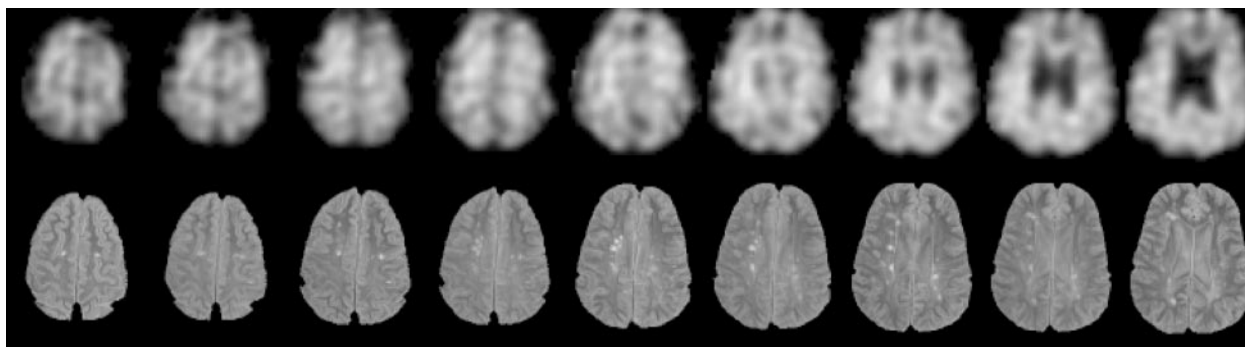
Example of nine axial sections used in quantification of metabolites (NAA images, top) and lesions (FLAIR images, bottom).
